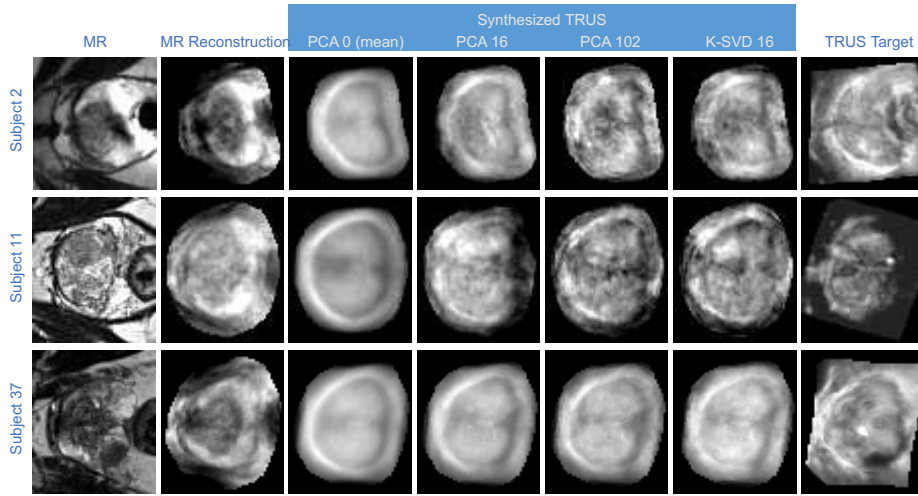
Example MRI-TRUS image synthesis results from three subjects. From left to right, we show each patient’s prostate MRI, the reconstructed MRI from the joint appearance model (using PCA 102), synthesized TRUS images found using both the PCA and dictionary learning (K-SVD) methods, and the patient’s target TRUS image. Here, PCA X indicates that X eigenvectors were used for the synthesis, with PCA 0 indicating that the mean TRUS image. K-SVD 16 indicates a sparsity constraint of 16 atoms for the synthesis.
